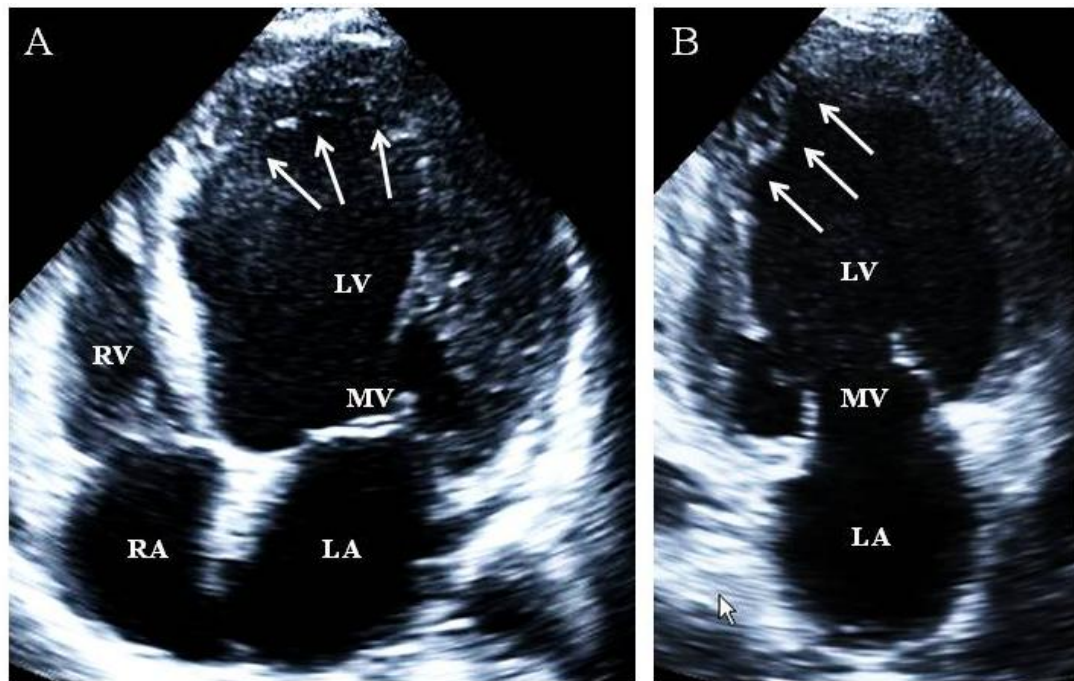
Two-dimensional echocardiographic images with four-chamber (A) and two-chamber views (B). Noncompaction cardiomyopathy is characterized by prominent myocardial trabeculations and deep intertrabecular recesses (see white arrows).
